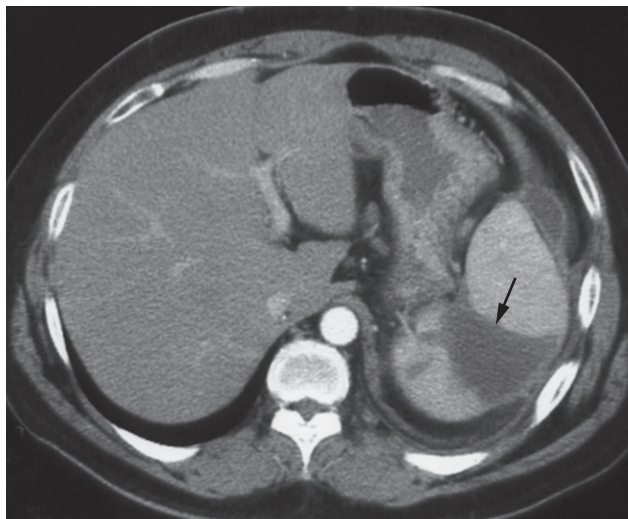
Splenic infarction. CT with contrast demonstrating a wedge-shaped, non-enhancing segment of spleen (arrow) consistent with infarction.
